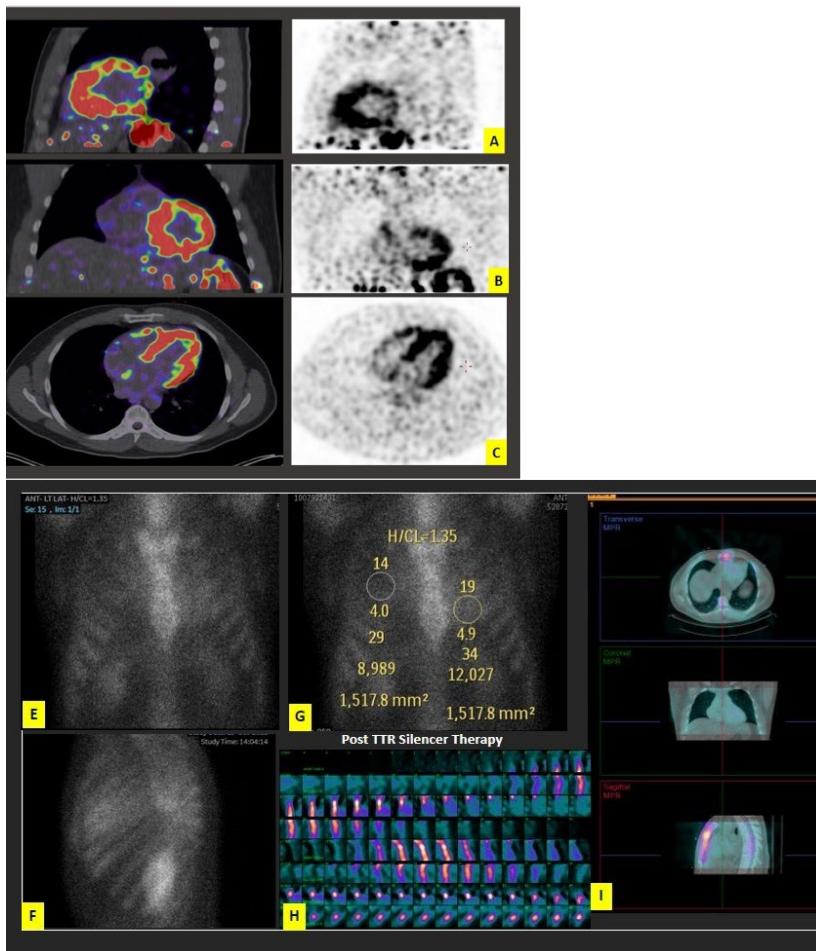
Post TTR gene silencer therapy 124I-evuzamitide PET-CT scan images. (A) Transaxial, (B) coronal and (C) sagittal images demonstrate 124I-evuzamitide uptake in the left and right ventricle. Images were obtained 300 minutes after administration of tracer. Tc99m-PYP imaging was performed approximately 2 years after initiation of TTR gene silencer therapy. Images were obtained 3-hours post-infusion of radiotracer. Planar images demonstrate uptake over the cardiac silhouette less than rib uptake (Perugini visual grade 1), with heart to contralateral ratio (H:CL) of 1.35. (I) SPECT-CT imaging confirmed that radiotracer activity was limited to the left ventricular blood-pool, with no myocardial uptake, a significant change from the prior scan.
